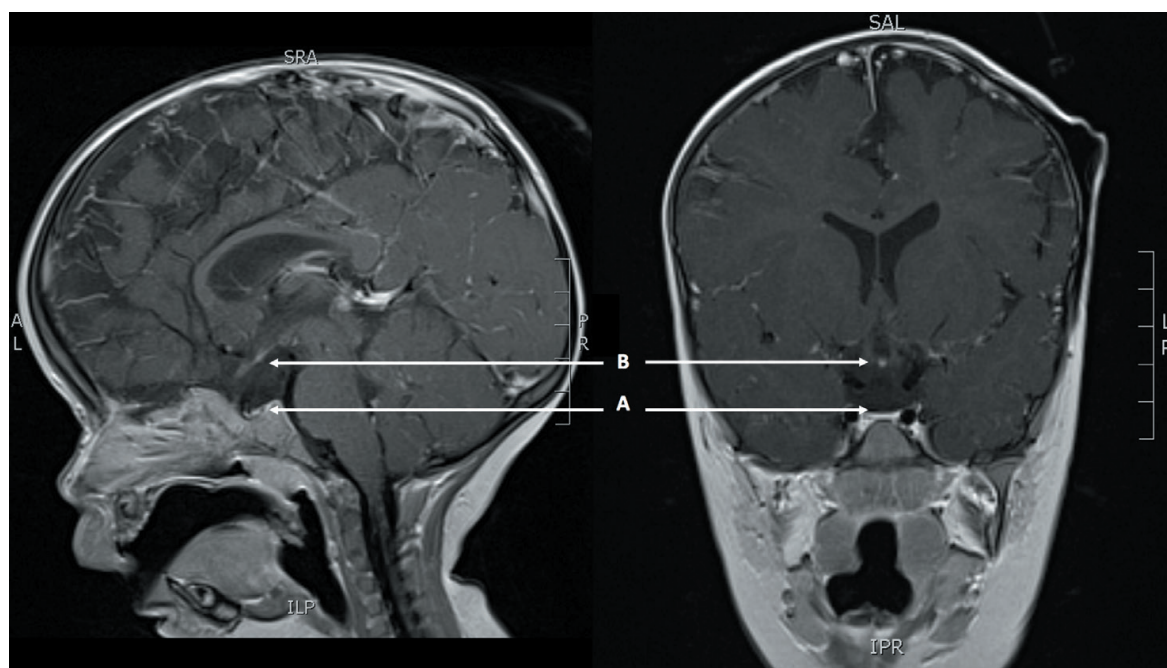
Sagittal and coronal MRI image of patient’s brain with pituitary malformation. The pituitary stalk is absent. Note (A) small anterior pituitary lobe, and (B) ectopic posterior pituitary lobe.
